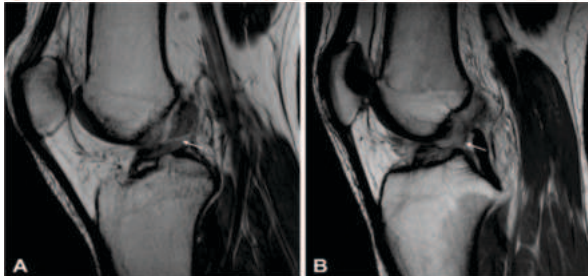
(A) A type III tear (arrow) is shown on the sagittal T1-weighted view and (B) another more complex type III tear (arrow) is shown on the sagittal T1-weighted view.
